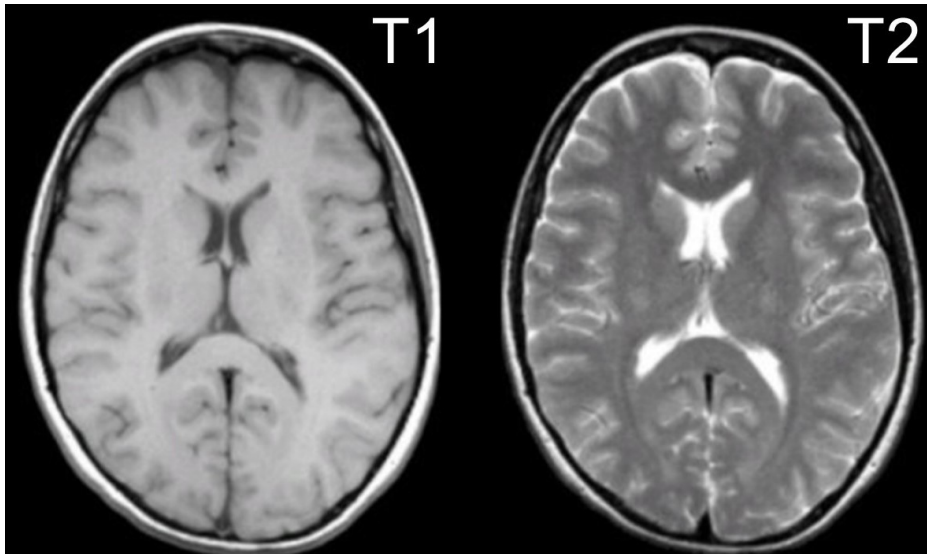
T1- and a T2-weighted image of a part of the brain, showing the contrast between the different imaging techniques.
